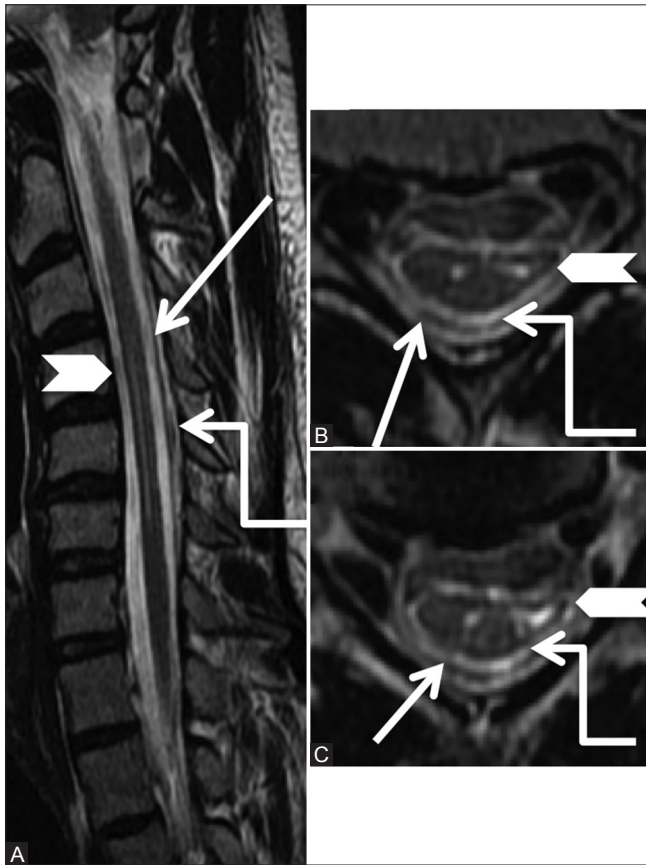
(A-C): Miscellaneous: Hirayama's disease: Sagittal T2-weighted (A) image in the flexion position shows atrophy of the cervical cord with hyperintense signal from C4-6 levels (arrowhead) and forward migration of the posterior dura (arrow). Axial T2-weighted (B, C) images at C5-6 level shows asymmetric atrophy of the left side of the cord with myelomalacic changes along with widened posterior epidural space (elbow arrow)
